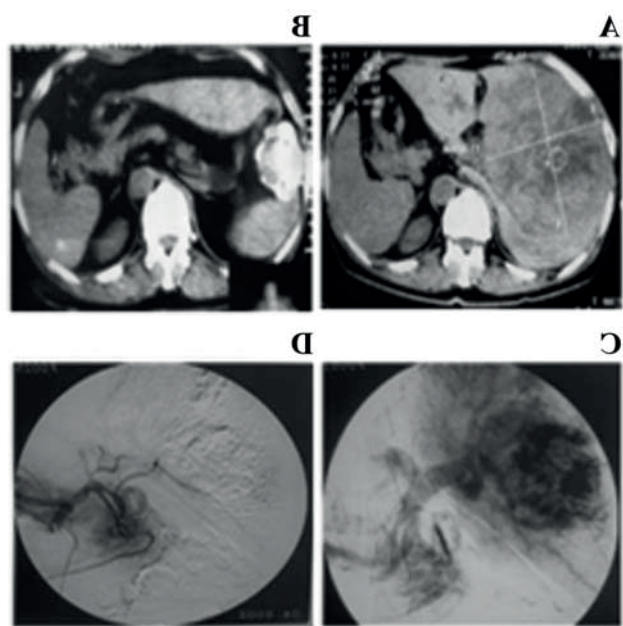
Spinal multi-slice CT scan and angiograms of a patient with liver tumor. A: A multi-slice CT scan before treatment showed that the patient had a large liver tumor measuring 14x13 cm² in plane. B: After six months of treatment the CT scan showed a decrease in tumor size to 7x6 cm² in plane. C: Angiography of the liver artery and portal angiography. D: The angiography taken just after treatment with TOCE showed that the right liver artery had complete embolization.
